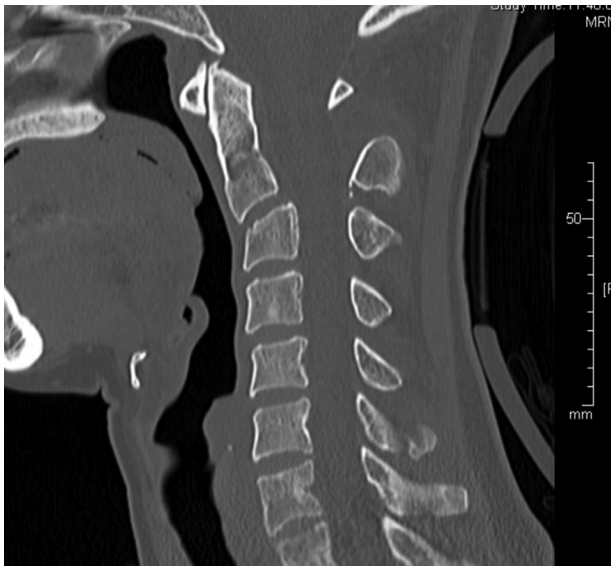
Sagittal CT slice of C2–C3 subluxation on Effendi type II fracture in case 1.
